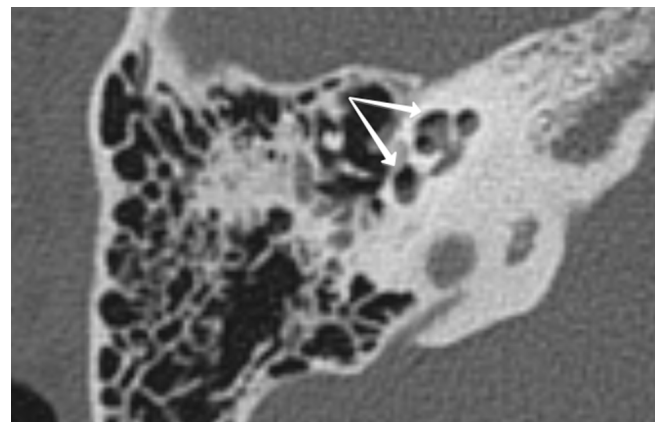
CT scan performed during the early postoperative period, right temporal bone of patient S. aged 37: the presence of air in the cochlea and vestibule
